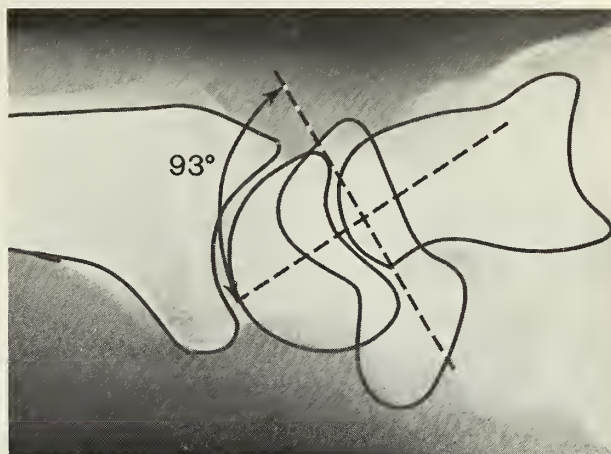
Radiograph showing the dorsiflexion instability pattern following a scaphoid fracture. The fracture of the scaphoid is not apparent in this lateral view but the 93° angle between the scaphoid and lunate is abnormal indicating instability.
